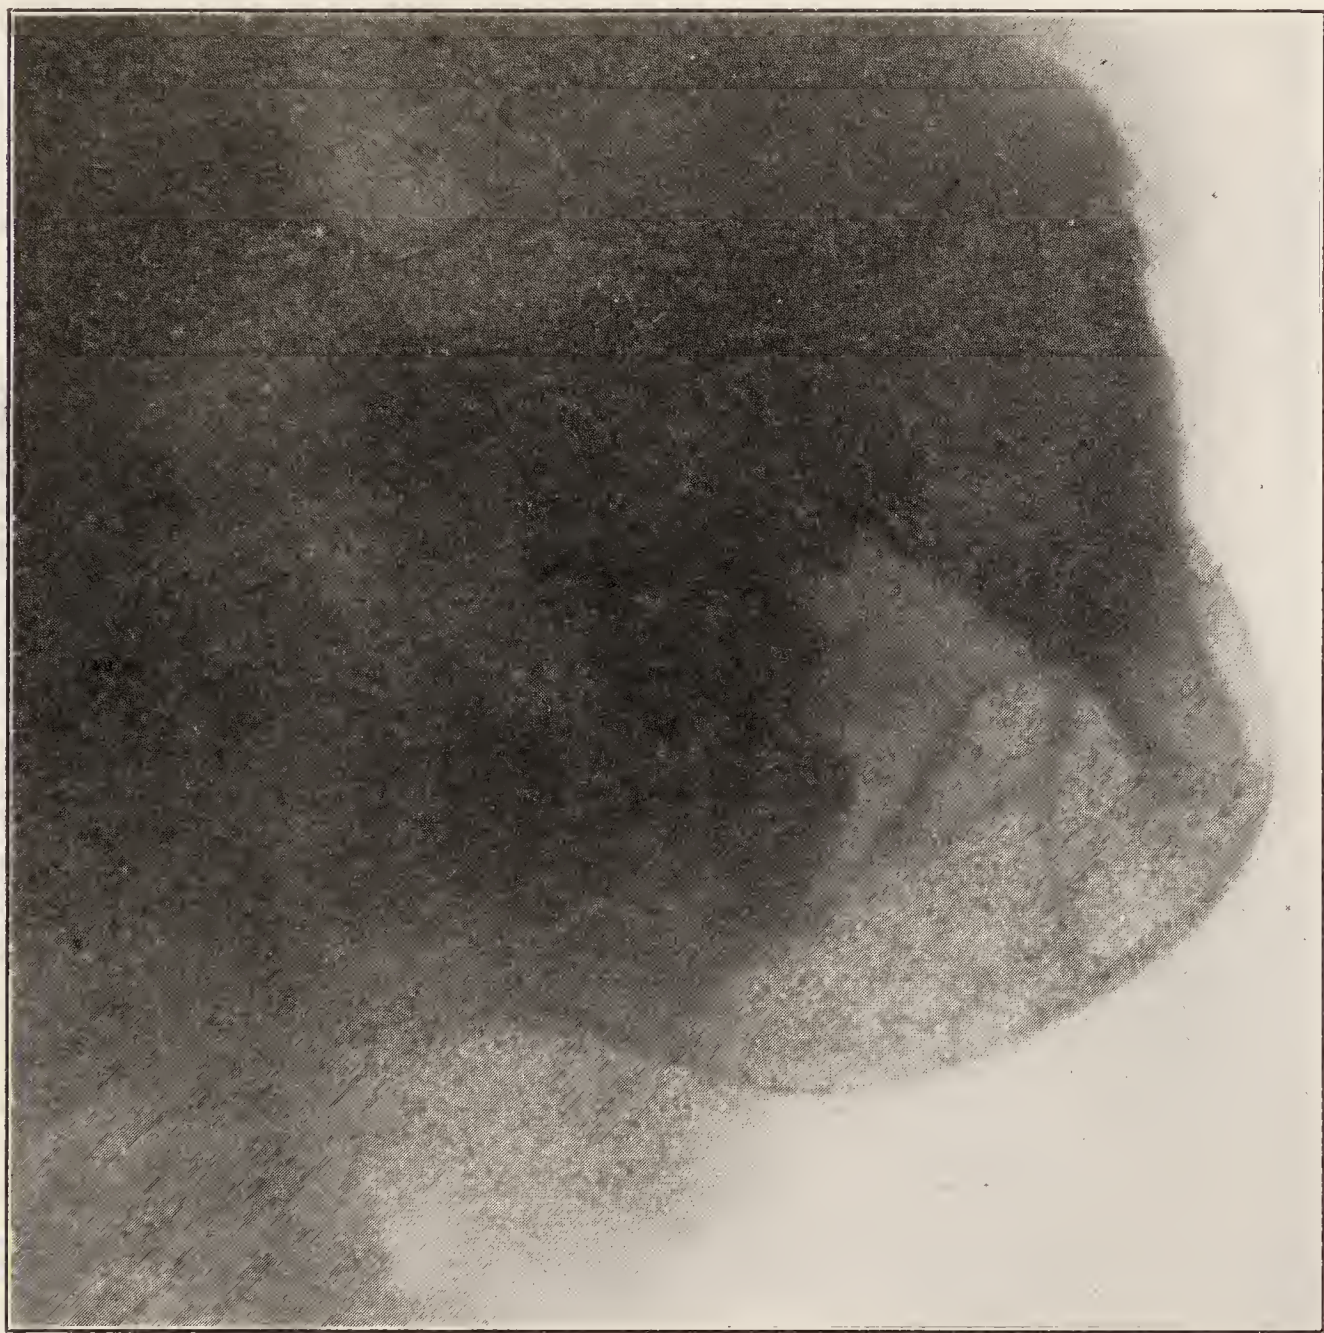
X-ray showing the destruction of bone and third bicuspid tooth.
